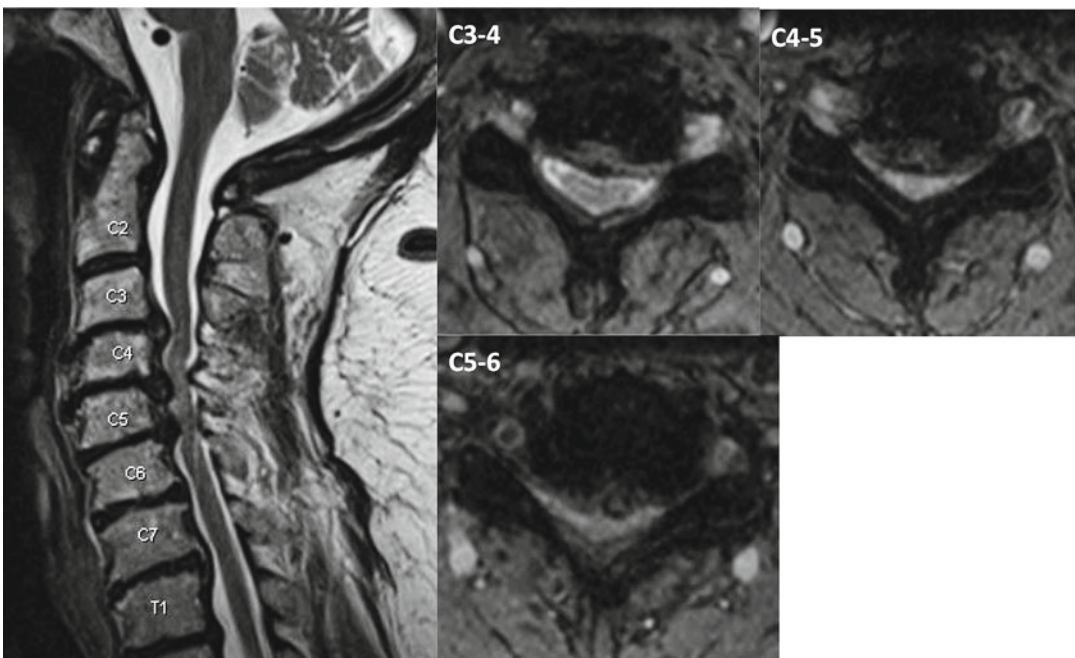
Preoperative cervical MRI of a 78-year-old woman with progressive cervical myelopathy demonstrating spinal cord compression from C3 to C6
